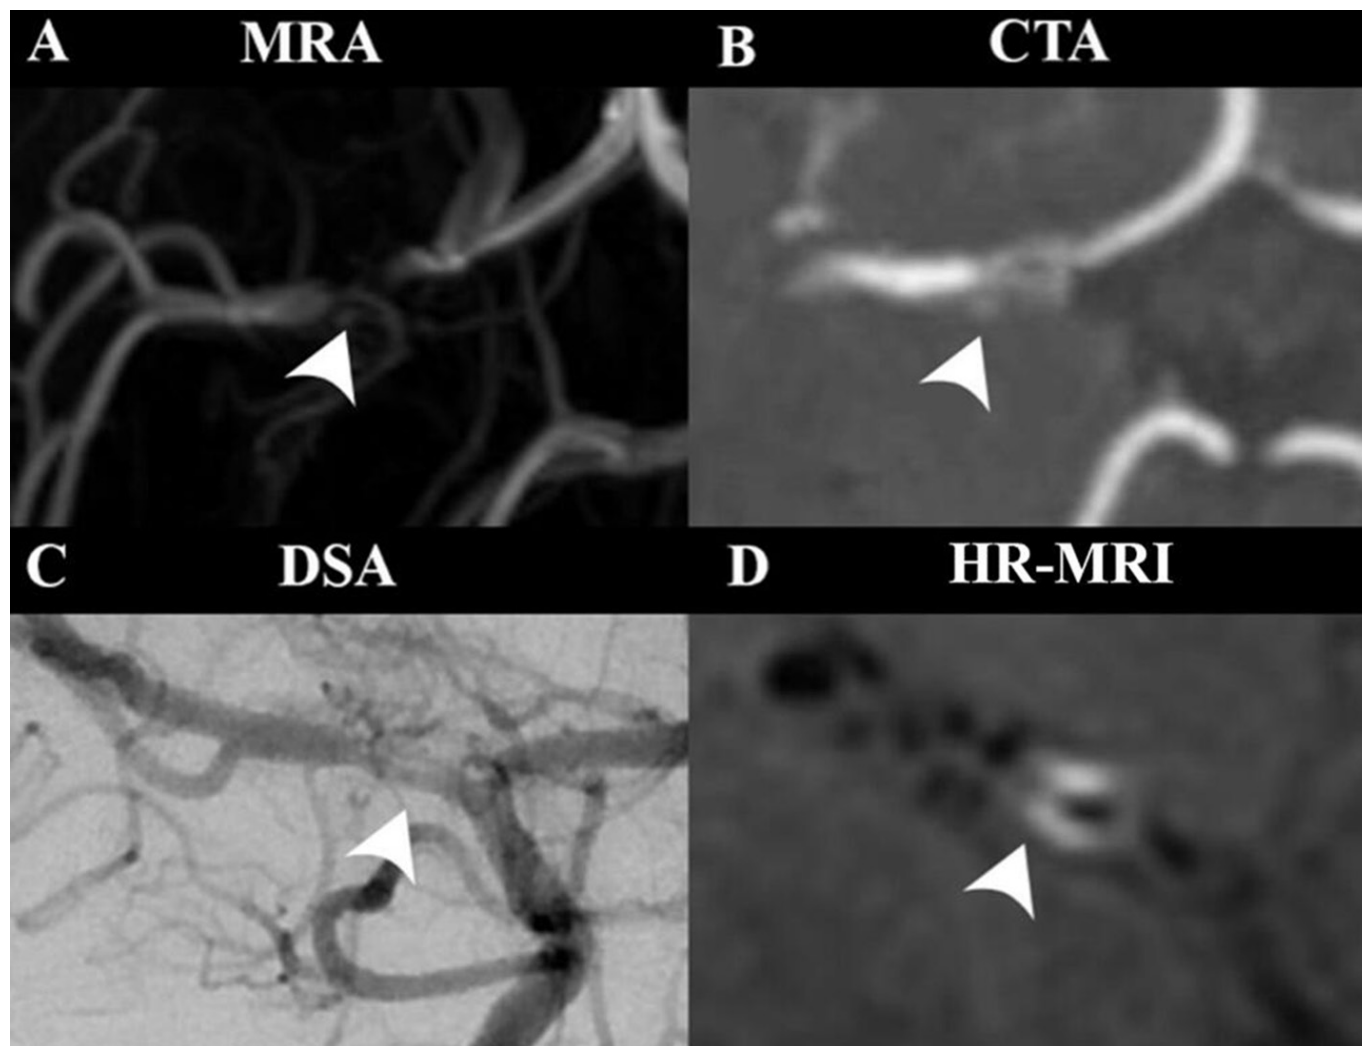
Imaging modalities for the assessment of intracranial atherosclerotic plaques. (A) Magnetic resonance angiography (MRA) shows a stenotic lesion (arrowhead) in the proximal segment of the middle cerebral artery (MCA). Nonetheless, it is not clear if the arterial segment is completely occluded or if there is a high-grade stenosis. (B) CT angiography (CTA) shows discontinuation of flow within the MCA (arrowhead). However, it is unclear if the affected arterial segment has an underlying plaque versus an area of dissection. (C) Digital subtraction angiography (DSA) shows a clear area of stenosis (arrowhead) with some neoangiogenesis. Based on the angiographic studies, it is unclear if the stenosis and Moyamoya-like neoangiogenesis is a primary Moyamoya disease versus a Moyamoya syndrome due to an advanced atherosclerotic process. (D) High-resolution MRI (HR-MRI) shows a heterogeneous gadolinium-enhancing plaque in the area of stenosis (arrowhead), suggesting that the neoangiogenesis is due to an advanced stenotic atherosclerotic process.
